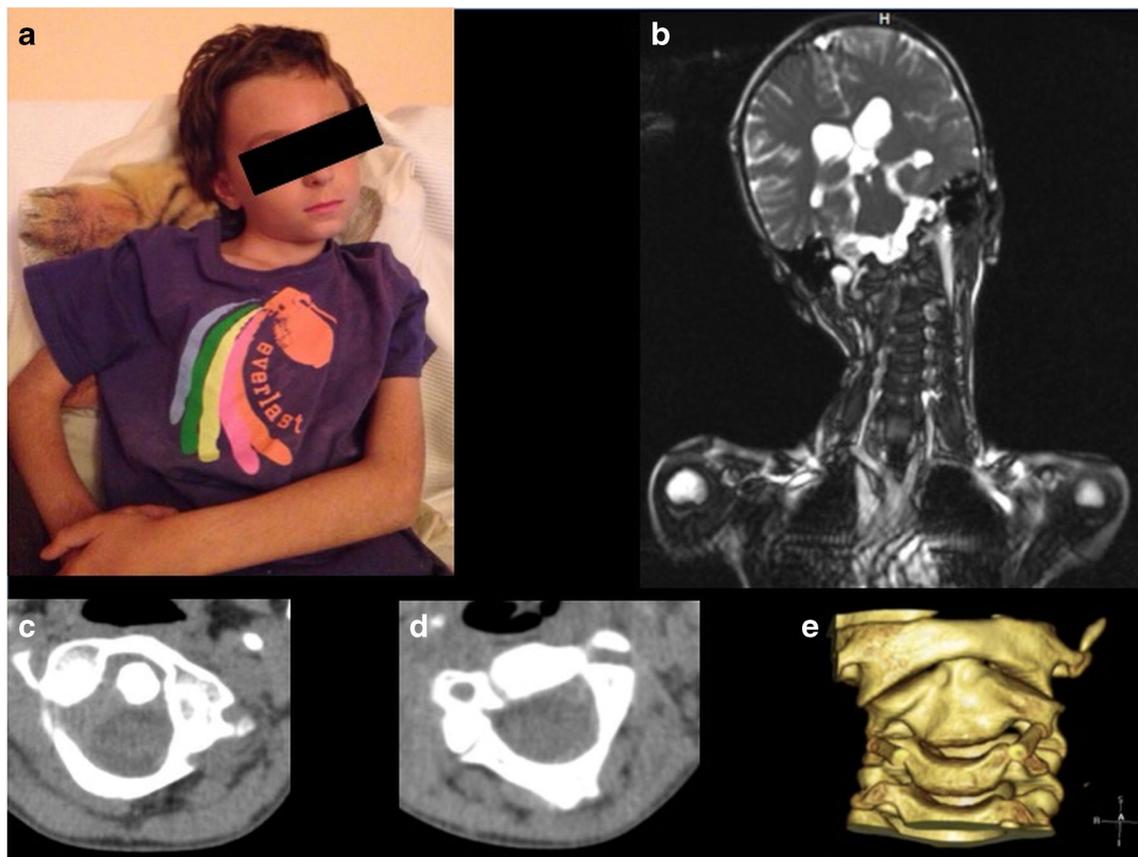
a Pre-operative photograph showing the patient with torticollis and the typical cock-robin head position. b Pre-operative coronal MR scout image of the cervical spine showing the torticollis. c–d Pre-operative axial CT images showing atlanto-axial rotatory fixation
